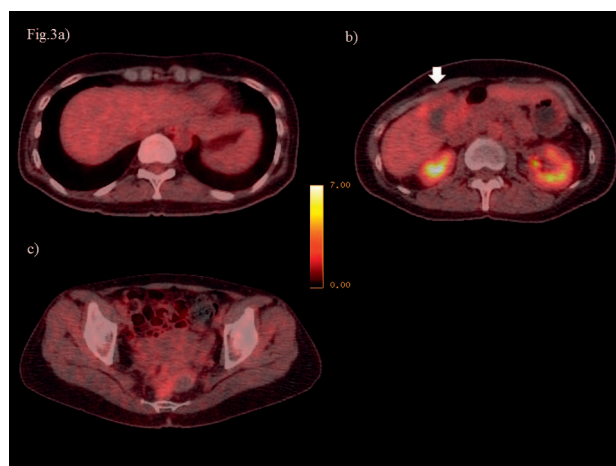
Changes in FDG-PET images after 6 cycles of chemotherapy. (a–c) FDG-PET showed that the gallbladder and liver tumor (arrow) was detected as only a slightly contrasted lesion in the liver. Moreover, there was no uptake of FDG in the distant organ metastases. FDG-PET, 18F-fluorodeoxyglucose-positron emission tomography.
